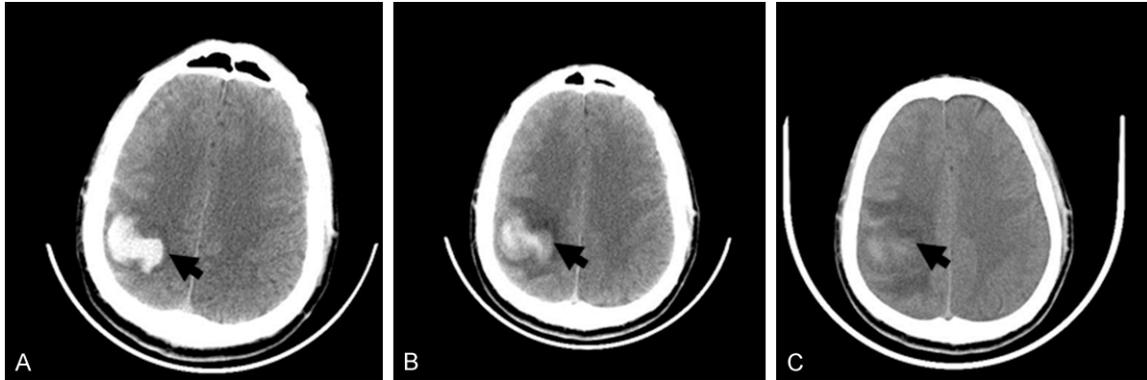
The hematoma analyzed by head CT imaging. Representative head CT images were shown. A. Head CT image at the onset of the disease. The hematoma (arrow) in the right parietal lobe was shown. B. Head CT image at 1 week after the onset of the disease. The hematoma (arrow) in the right parietal lobe was absorbed partly and the edema was obvious. C. Head CT image at 2 weeks after the onset of the disease. The hematoma (arrow) in the right parietal lobe was absorbed and edema was more obvious.
